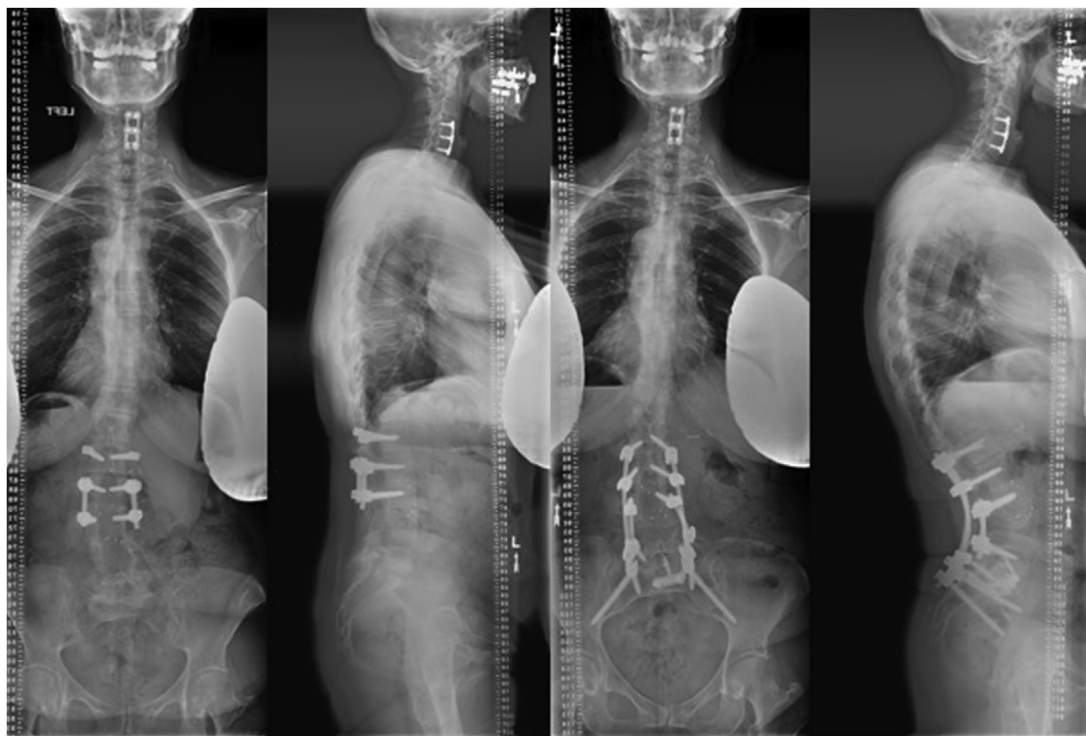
This is a 66-year-old woman with a prior L1-3 fusion and L3-4 laminectomies who presented with flat back syndrome, sagittal plane imbalance, and inability to stand erect. Preoperative AP and lateral radiographs (left) demonstrate sagittal vertical axis 8.5 cm, pelvic incidence-lumbar lordosis mismatch 60 to 27°, and pelvic tilt 37°. She underwent an L4 pedicle subtraction osteotomy, L1 to pelvis posterior instrumented fusion, and L5-S1 ALIF. Three-month postoperative AP and lateral radiographs (right) show excellent correction in her lumbar lordosis and sagittal alignment (sagittal vertical axis 0 cm, pelvic incidence-lumbar lordosis mismatch 60–60°, and pelvic tilt 24°). Coronal vertical axis remained well aligned pre- and postoperatively.
